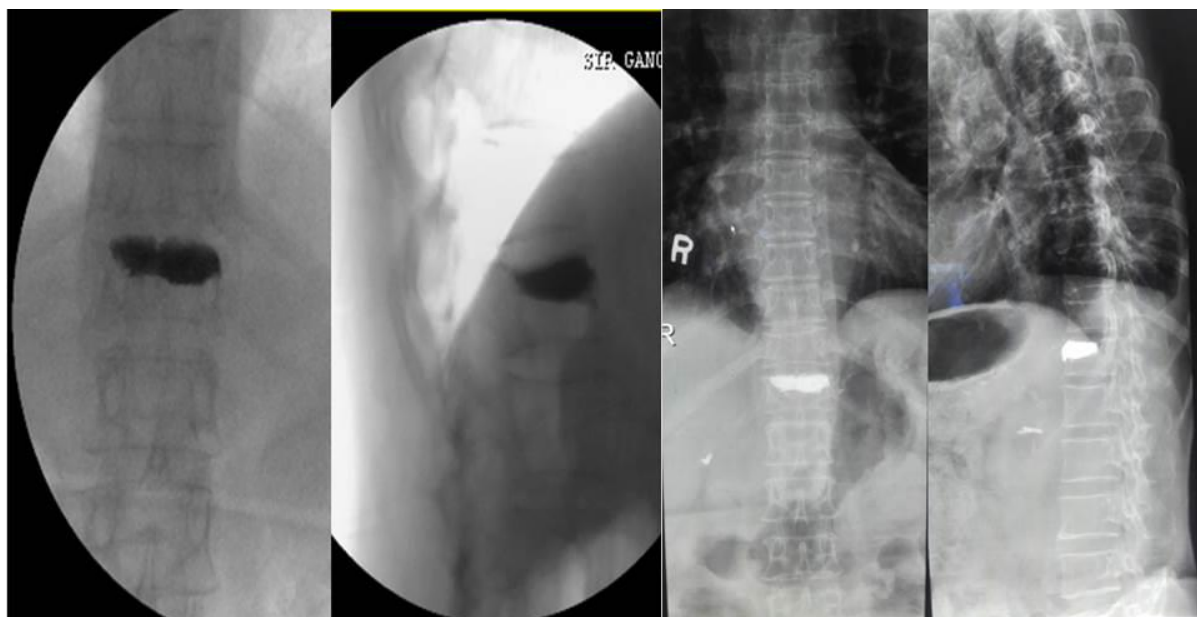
Post-operative X-ray after Percutaneous Balloon Kyphoplasty showing maintenance of vertebral body height
